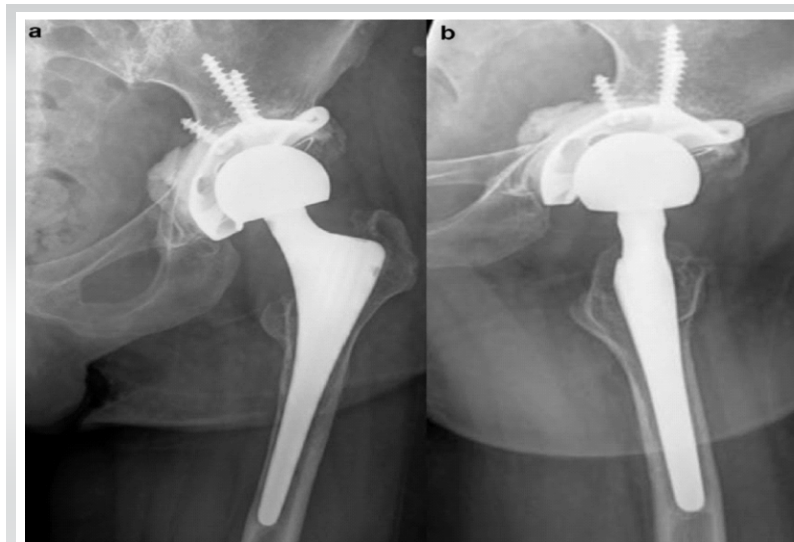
Follow-up X-ray. At 6 months, showing anteroposterior and lateral view
